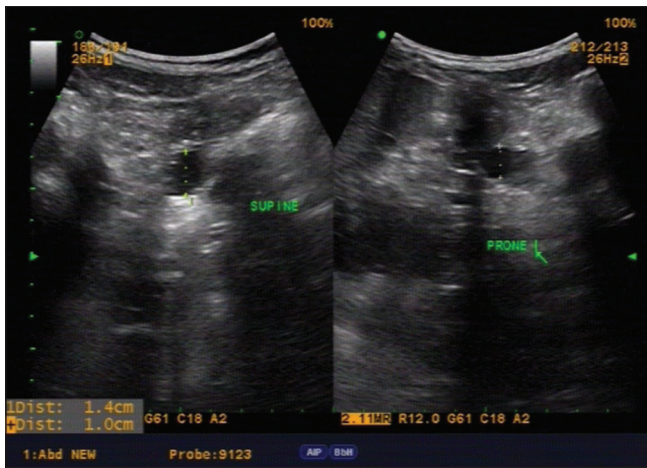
Post Pyeloplasty ultrasound showing APD of 14 mm in supine and 10 mm in prone position
